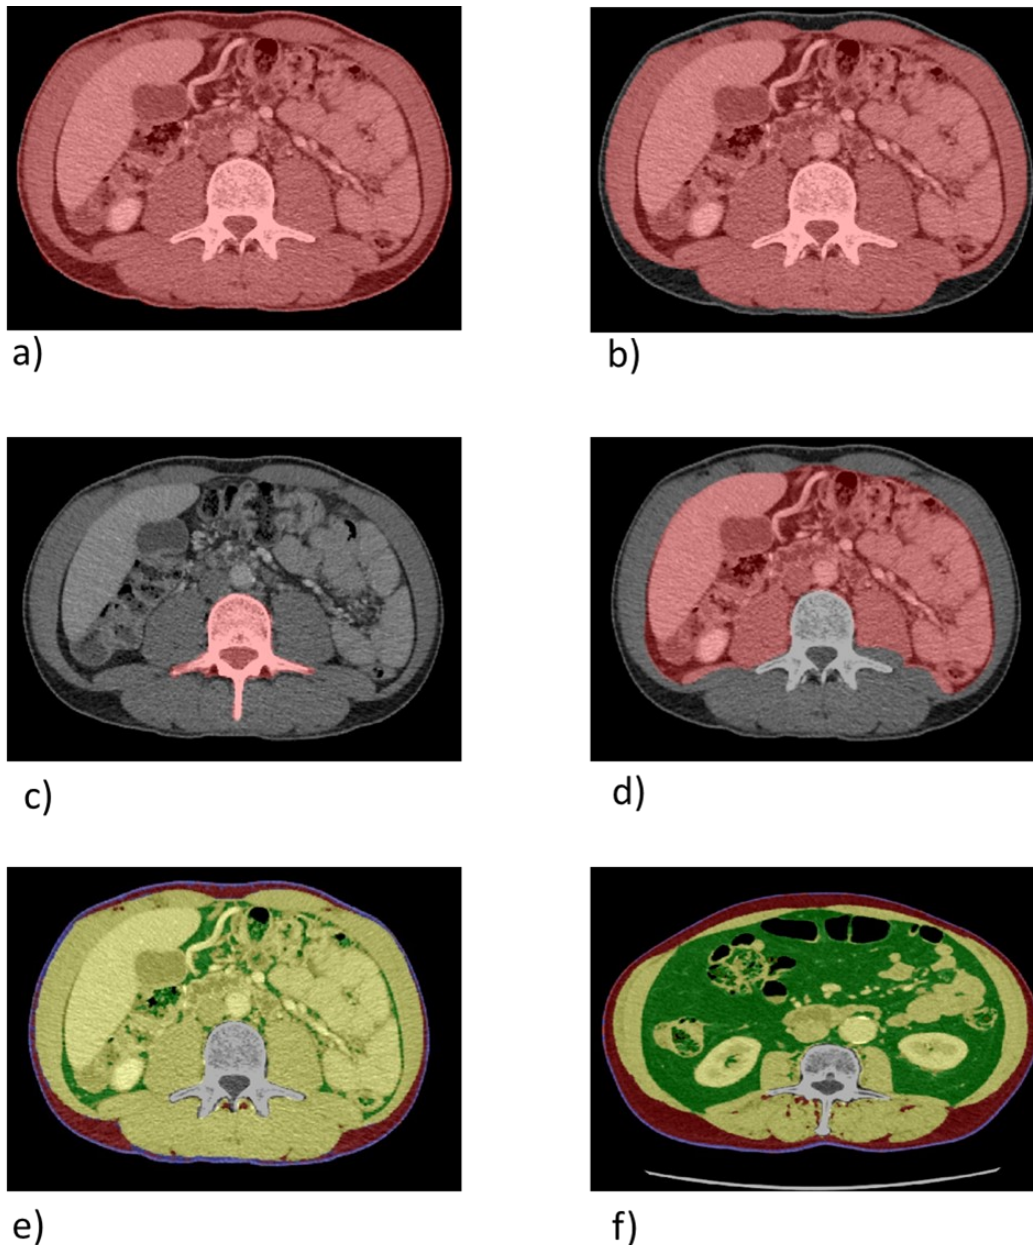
CT body composition segmentation at Lumbar 3 vertebrae: a) Subcutaneous boundary, b) Skeletal muscle boundary, c) Vertebral boundary, d) Visceral boundary, e) Fat segmentation 1, f) Fat segmentation 2
